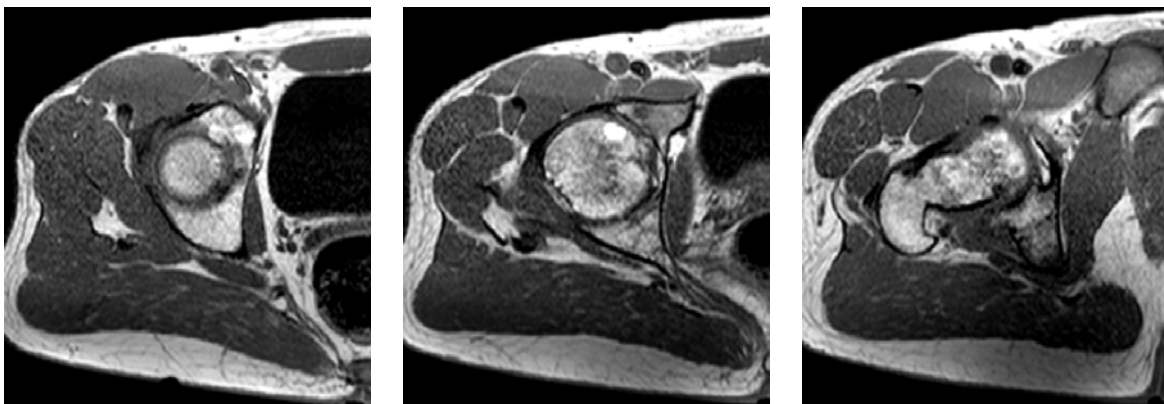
Sample slices from T1-weighted MRI showing the complexity of the femur joint (from superior to inferior)
